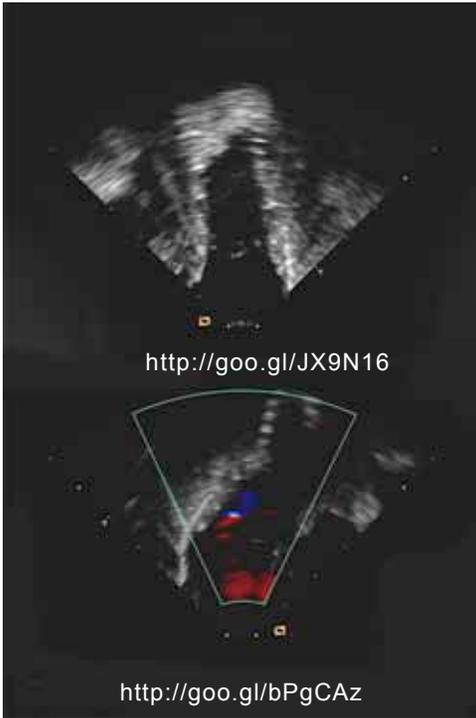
Intracardiac echocardiography at the end of the procedure, documenting the flail core matrix leaflet to be trapped beneath the stents, and normal movement of the Melody Valve leaflets, with only trace insufficiency.
